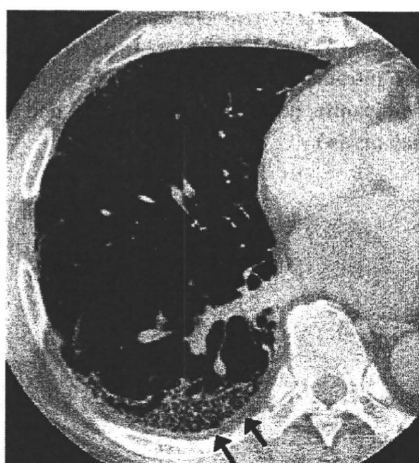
Nonspecific interstitial pneumonia (NSIP) associated with RA in a 54-year-old man. Transverse thin-section CT (1-mm collimation) at the level of the right inferior pulmonary vein demonstrates intralobular reticular opacity (arrows) with a predominantly peripheral distribution.
